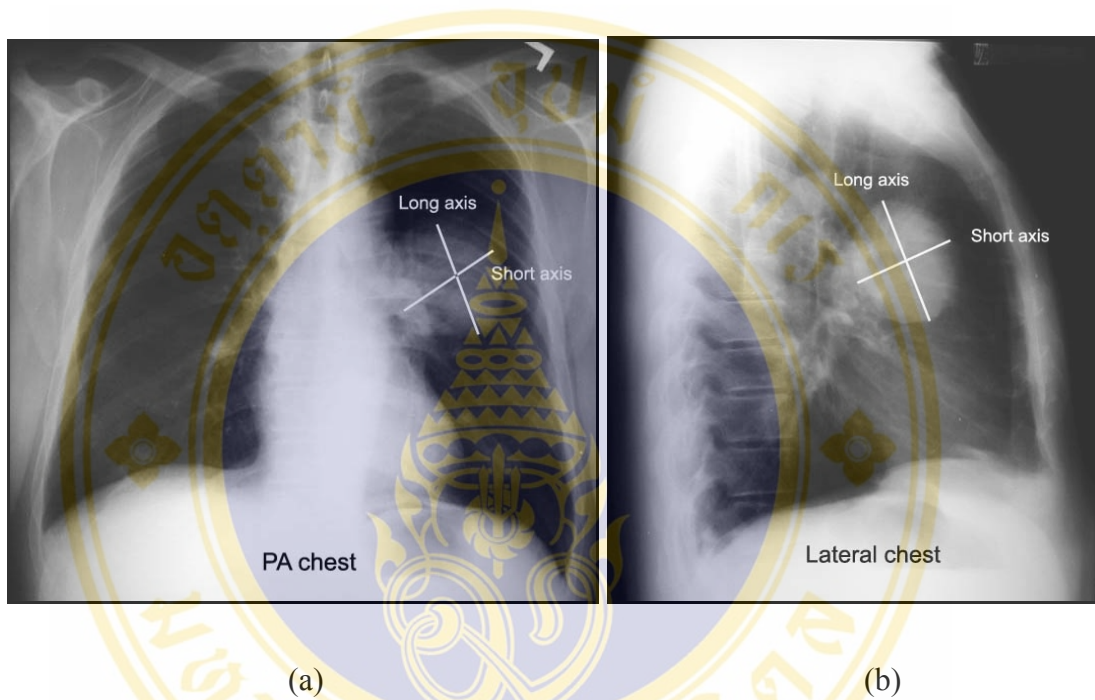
Measurement of tumor size from chest x-rays (50)
